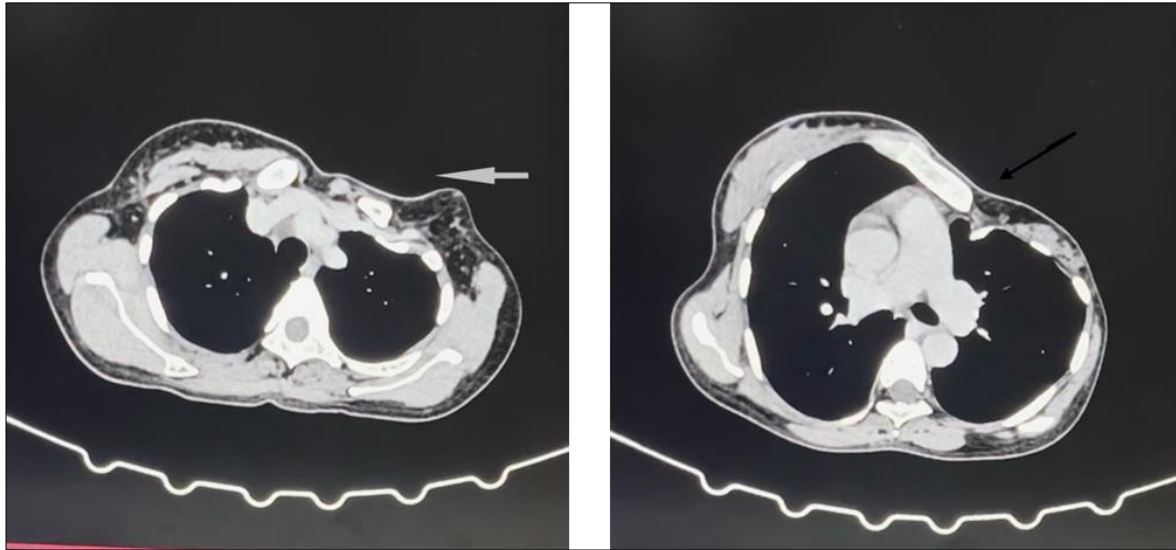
CT chest without contrast (axial view). The primitive pectoralis minor muscle and the undeveloped left pectoralis major muscle are depicted by the arrows)
